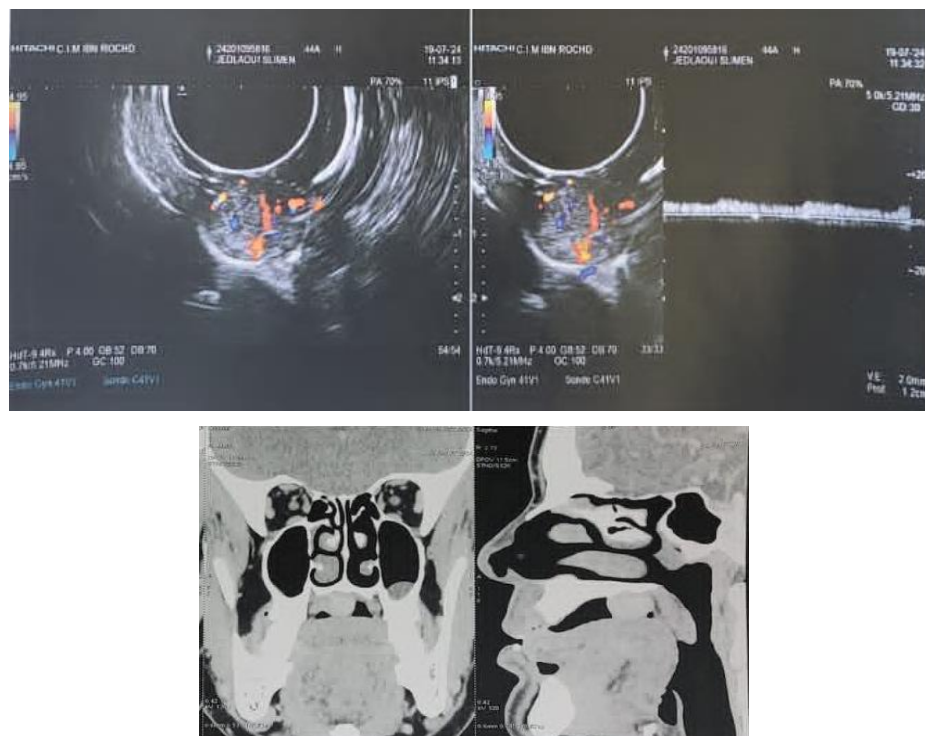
Ultrasonography of the soft tissues
